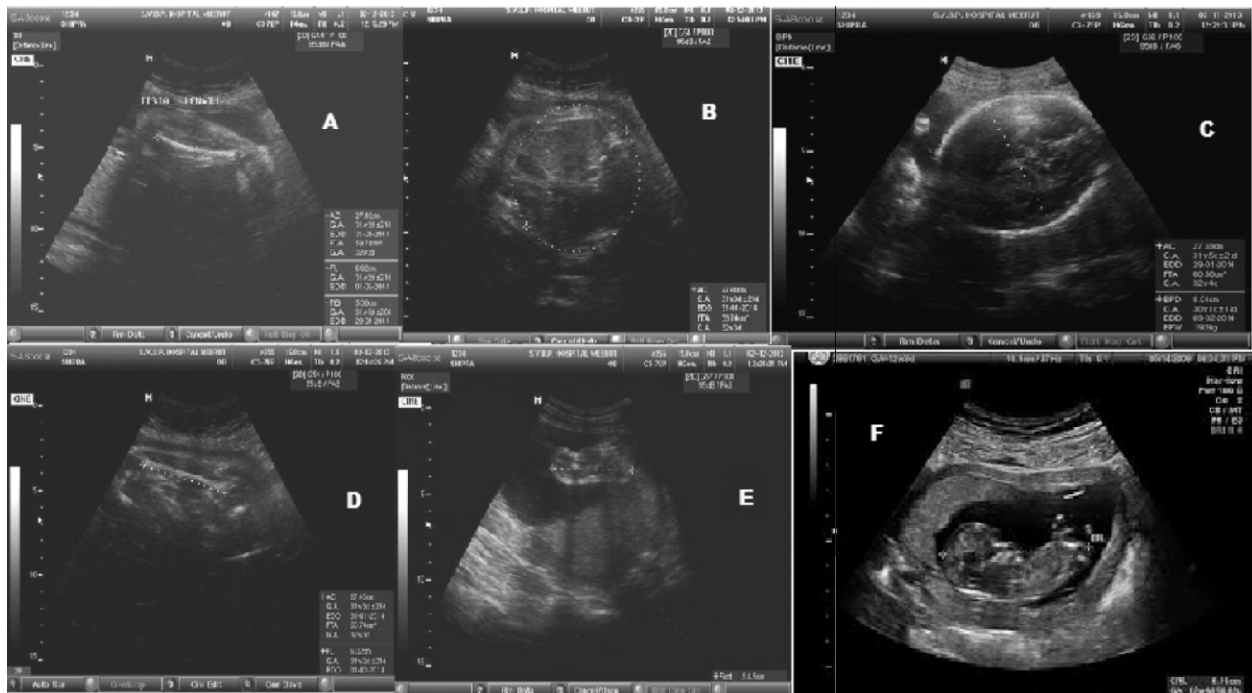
Ultra sonogram of 12-26 weeks of fetus showing A: Tibial length, B: Abdominal circumference, C: Biparietal Diameter, D: Femur length, E: Foot length and F: Crown Rump Length.
